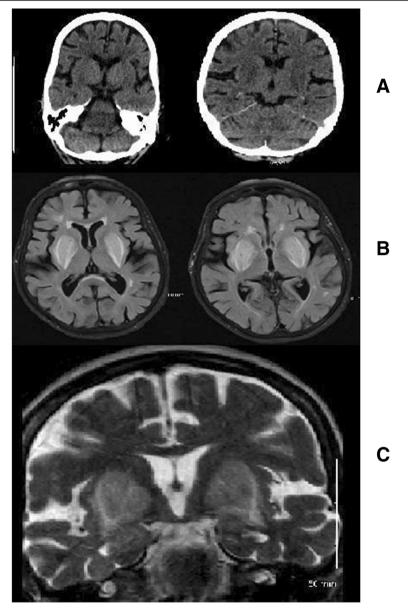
Showing CT Scan and MRI Brain images. a CT-brain showing bilateral symmetrical hypodensity in the basal ganglia. b MRI Brain axial FLAIR sequence. c MRI brain coronal T2 sequences both showing bilateral symmetrical swollen lentiform nuclei with a hyperintense T2/FLAIR signal rim delineating the boundaries of the putamen
